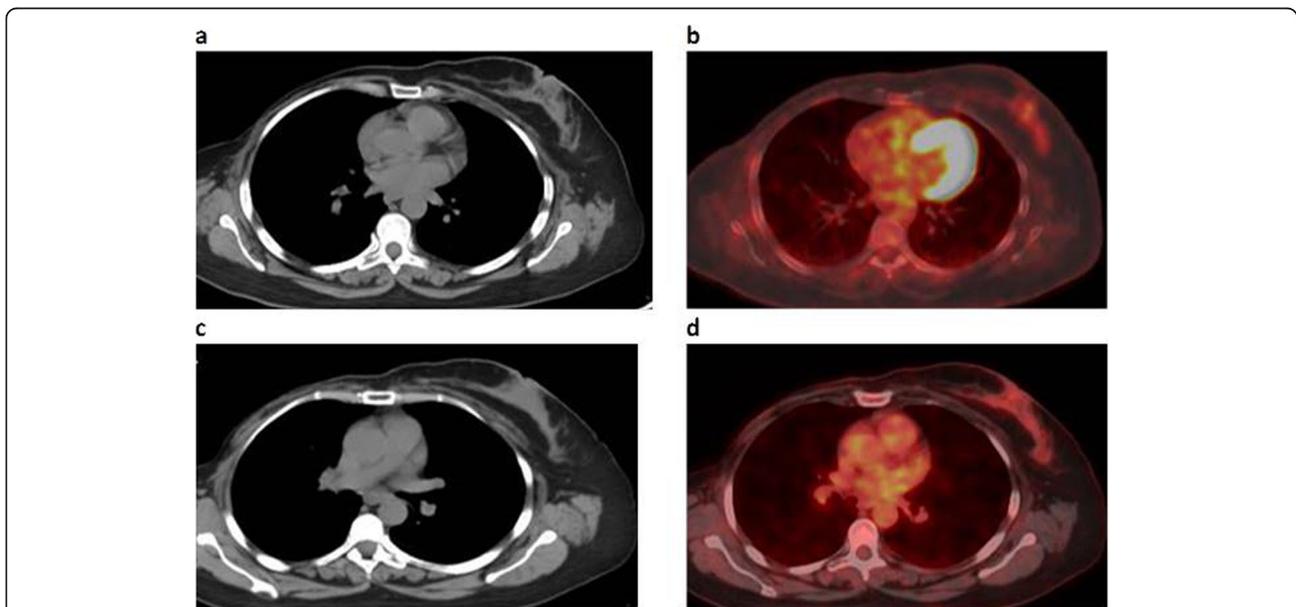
56 years old female patient with history of right breast cancer submitted for MRM followed by chemotherapy presented with left breast cancer (invasive ductal carcinoma, luminal B subtype). Axial CECT and fused PET/CT images (a, b) revealed metabolically active left breast soft tissue mass lesion achieving 3 SUL_{peak} . On follow-up after completion of chemotherapy, stationary appearance of the left breast mass regarding size and FDG uptake is noted in both axial CECT and fused PET/CT images (c, d) denoting stationary disease and stationary metabolic disease
